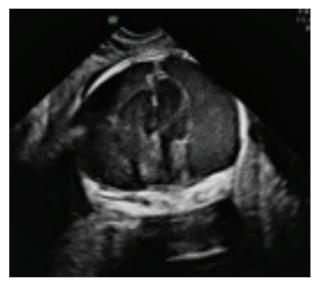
A coronal view of extenden subarachnoid space of the brain in ultrasonography
